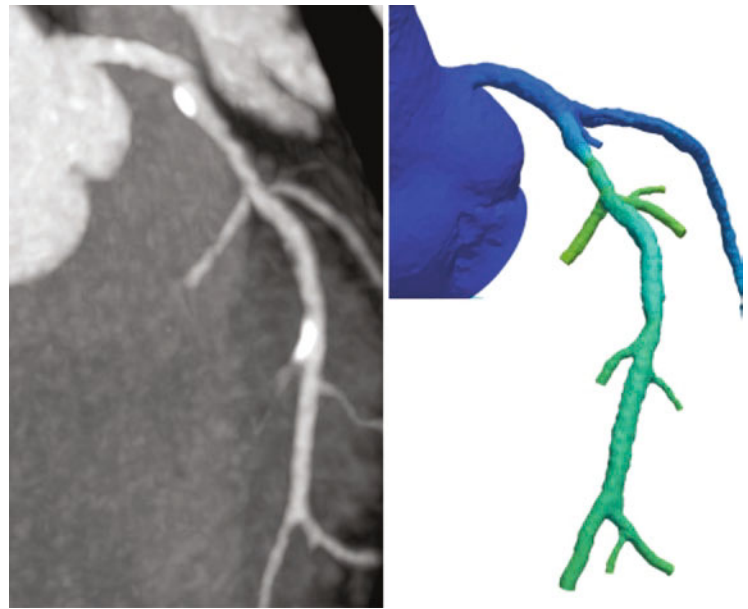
Findings from a 70-year-old woman with hypertension, hyperlipidemia, and angina symptoms. Coronary CTA demonstrates a noncalcified plaque in the LAD artery with estimated 50–70% luminal stenosis. By quantitative coronary angiography, it measured 58% stenosis. However, it was not ischemia-producing by either  $FFR_{CT}$  or FFR
